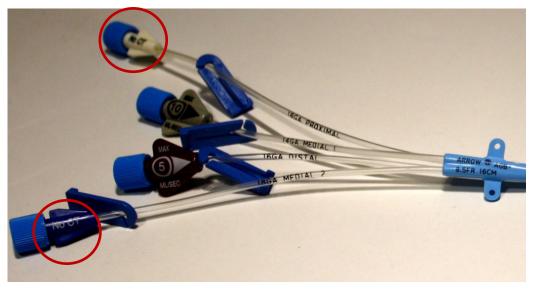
Example of 'No CT" labelling on CVC. Courtesy of Teleflex Incorporated³⁶
